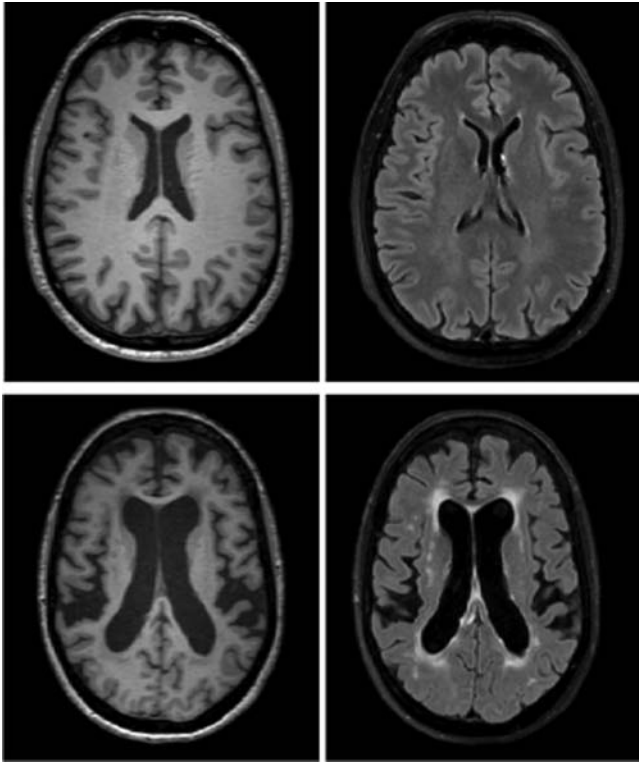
Examples of normal and accelerated brain aging. The MR images of older adults include a T1-weighted acquisition (left side) and a fluid-attenuated inversion recovery (FLAIR) acquisition (right side). The top images are of an individual with normal brain aging, while the bottom images are of an individual with accelerated brain aging. Specifically, the bottom image shows greater cortical atrophy and larger ventricles. The bottom image also shows greater severity of white matter hyperintensities, displayed as bright regions in the brain tissue on the FLAIR image.
